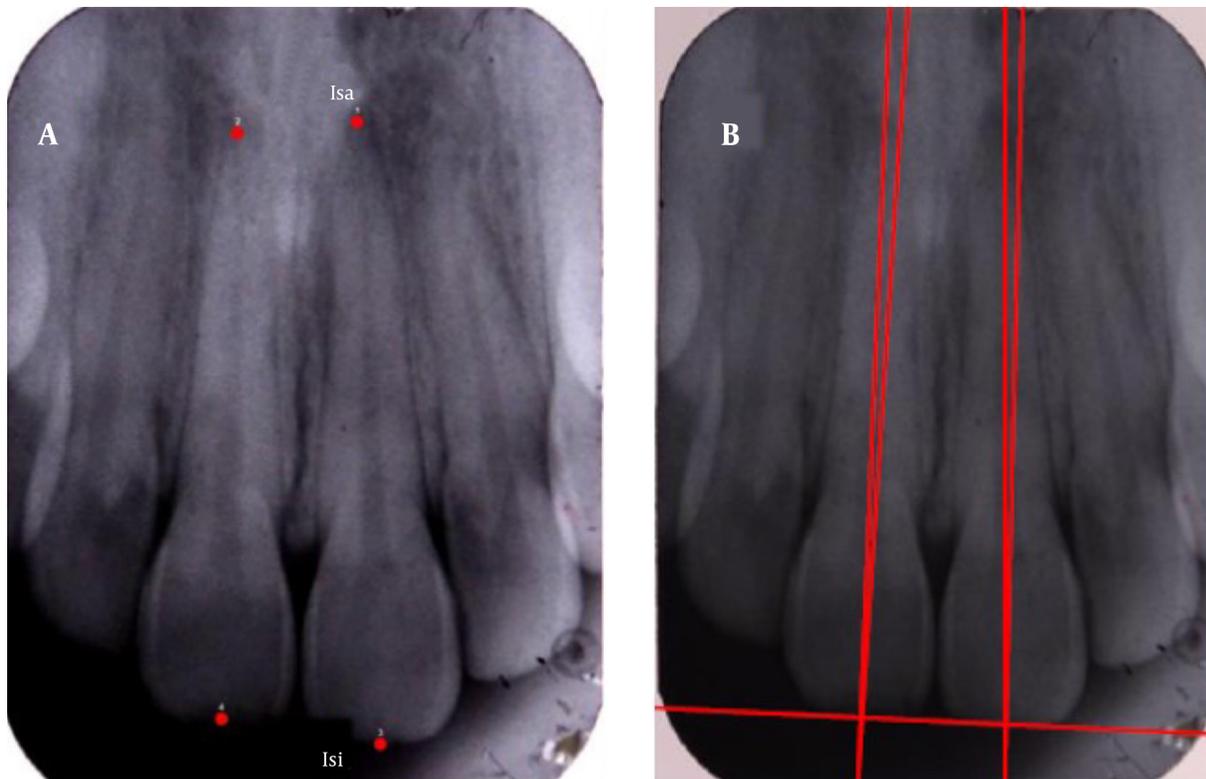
Measurement of incisor angulation in PA radiographs
